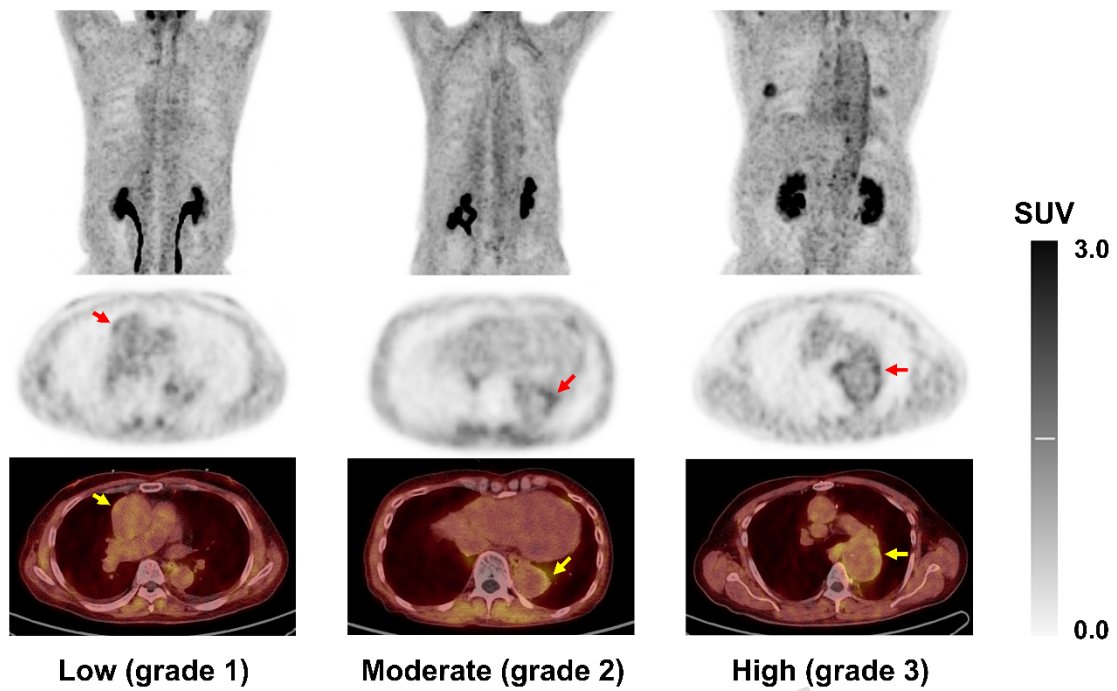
Representative cases of ^{68}Ga -FAPI-46 PET. An uptake indiscernible from the blood pool activity was classified as grade 1. Discernible but mild uptake, and prominent uptake were classified as grade 2 and 3, respectively. Arrows show uptakes in the aortic aneurysm. SUV = standardized uptake value.
